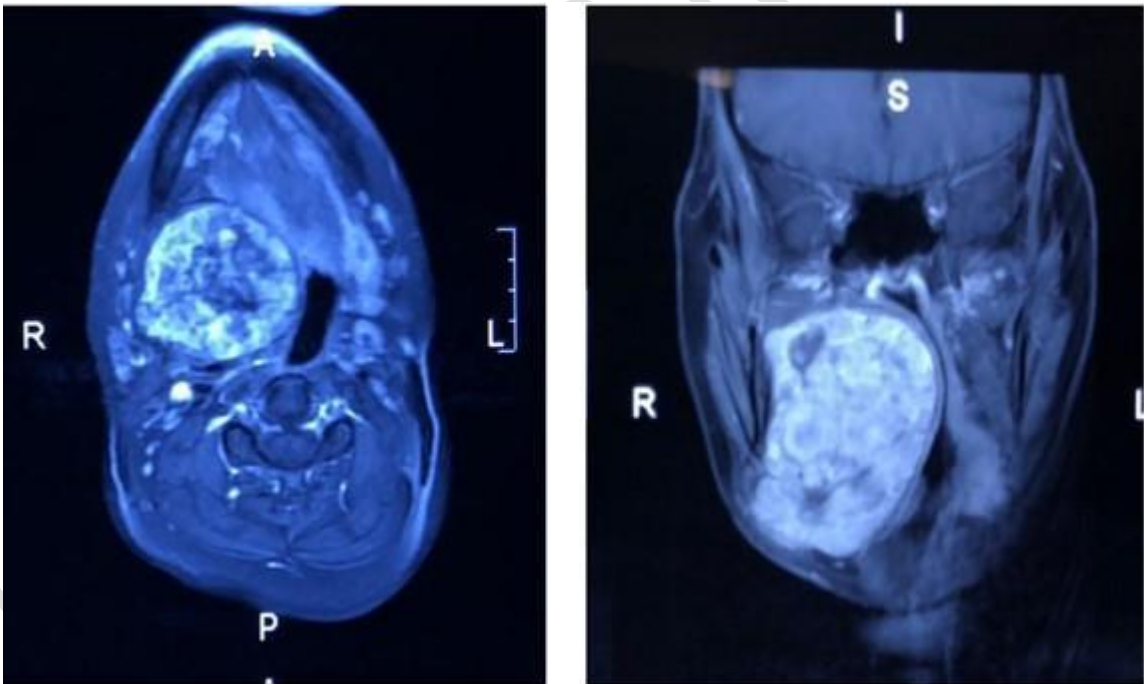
CT Head showing the enhancing lesion arising from the submandibular gland
